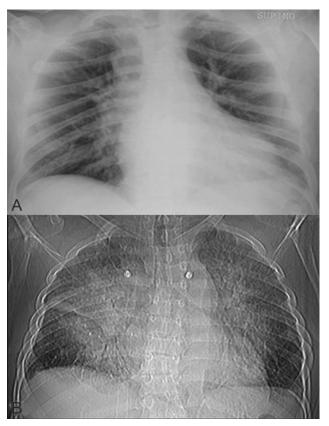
Supine frontal chest radiograph on admission (A), and scout view obtained 4 hours later (B).
